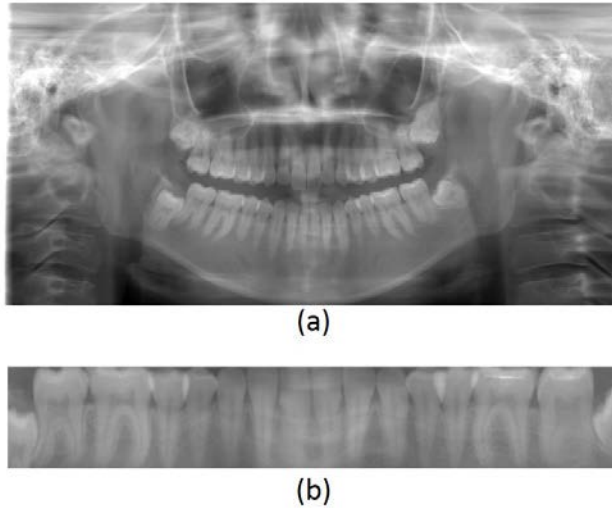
Image transformation. (a) Original dental panoramic radiograph and (b) standardized dentition image
